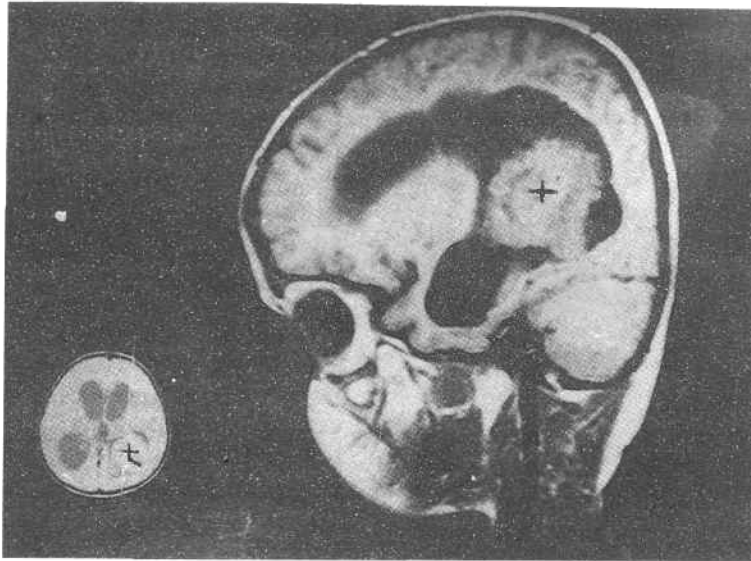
Magnetic resonance imaging transverse and parasagittal sections showing the intraventricular tumor.
